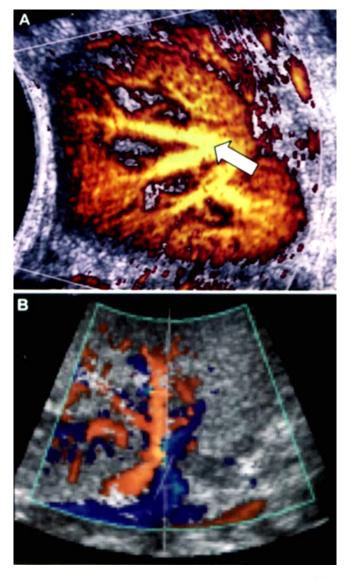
Doppler ultrasound scan of (A) a control rhesus kidney allograft showing normal blood flow with *arrow* identifying robust blood flow; (B) obstructed blood flow in a kidney allograft after perfusion with UW solution containing crystalline particles
